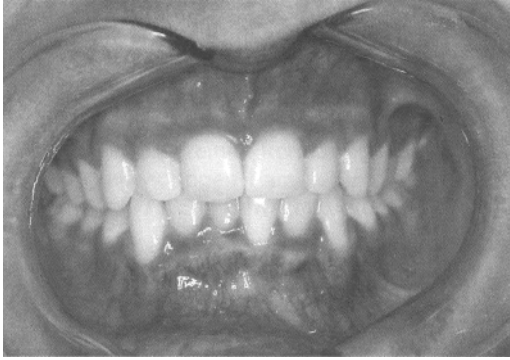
Typical findings of a high individual caries risk with few fillings, poor saliva values and high diet-related caries activity. The wing bite radiograph already shows five proximal decalcifications (PFs)
